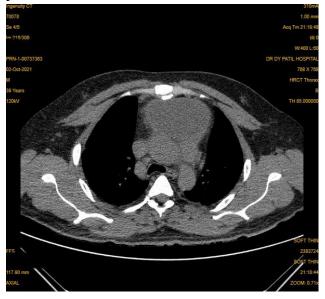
HRCT thorax findings: Axial section of soft tissue window showing Loculated pericardial effusion into lateral and base of heart causing mass effect on heart.
